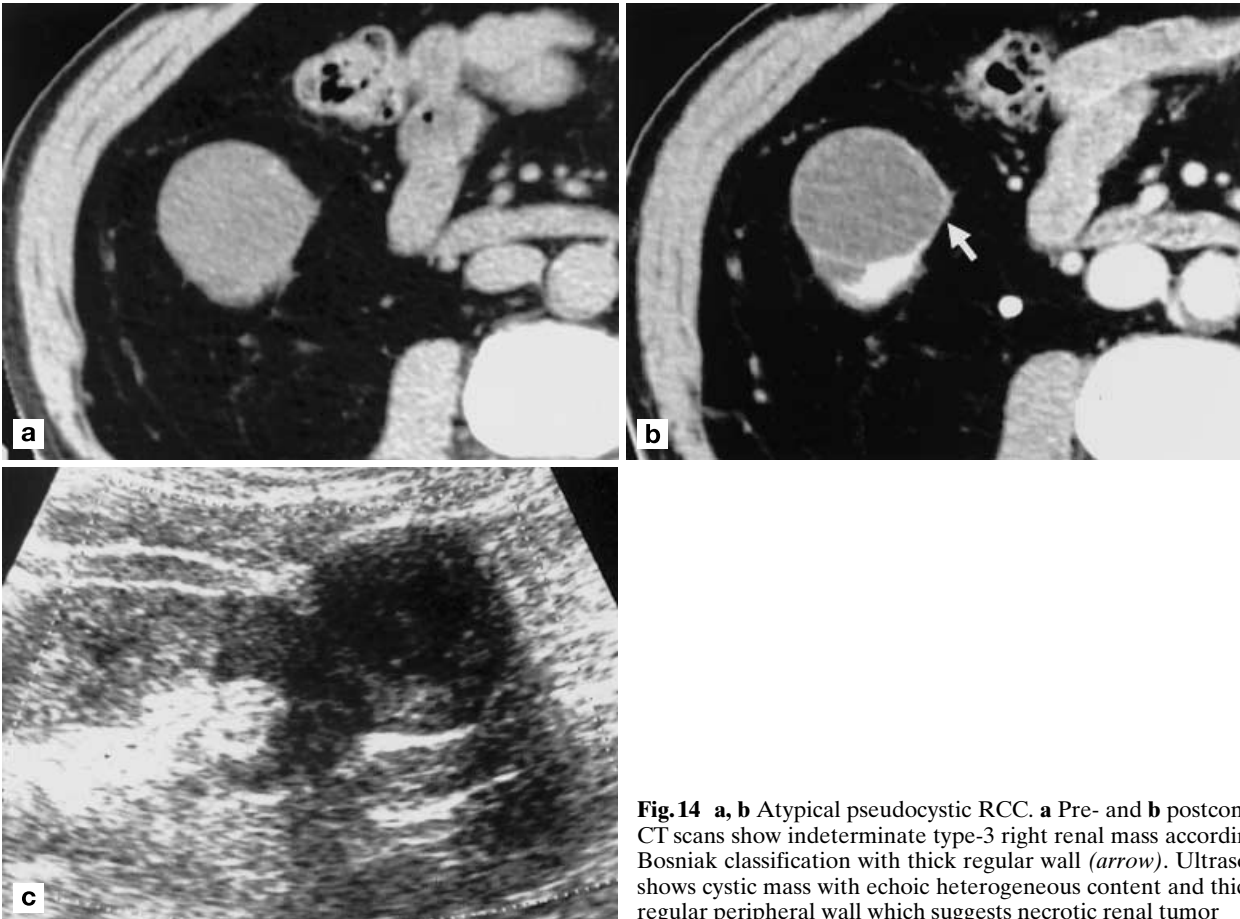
a, b Atypical pseudocystic RCC. a Pre- and b postcontrast CT scans show indeterminate type-3 right renal mass according to Bosniak classification with thick regular wall (*arrow*). Ultrasound shows cystic mass with echoic heterogeneous content and thick irregular peripheral wall which suggests necrotic renal tumor
